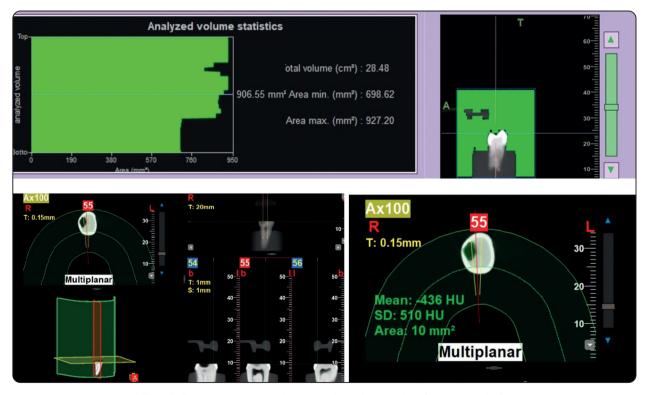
Cone beam computed tomography volume and surface area analysis
